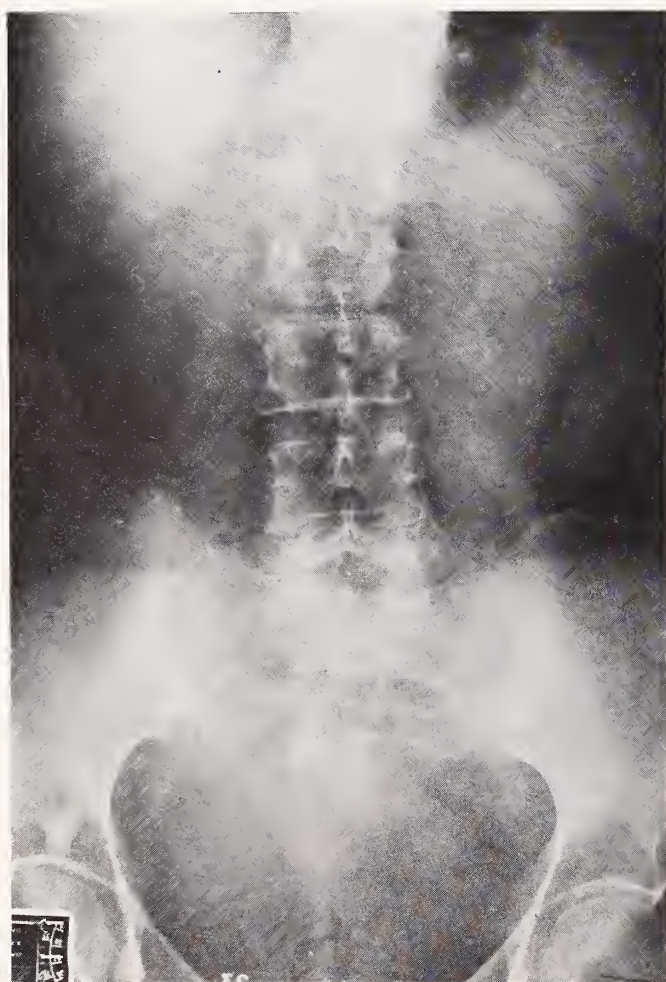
Typical appearance of the gasless abdomen and no air-fluid levels in the plain flat and upright abdominal radiograph.
